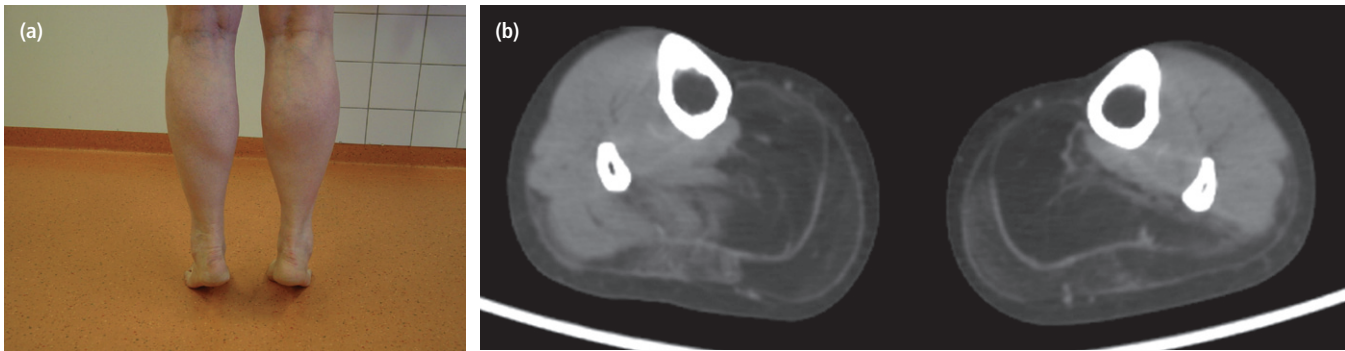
Distal myopathy caused by mutations in the gene encoding anoctamin 5. (a) The patient is not able to stand fully on tiptoe on the left side. The left calf is smaller compared to the right side. (b) CT scan shows fatty replacement of the calf muscles of both legs, left slightly more than right.
